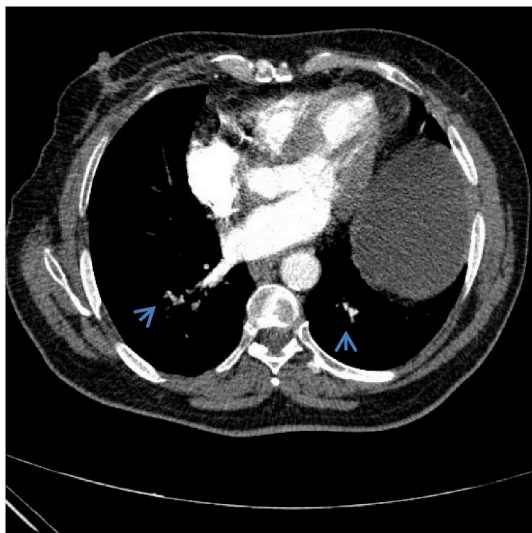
71-year-old woman with cirrhosis. CT pulmonary angiography shows pulmonary emboli with abrupt caliber change in bilateral lower lobe artery (arrows).
